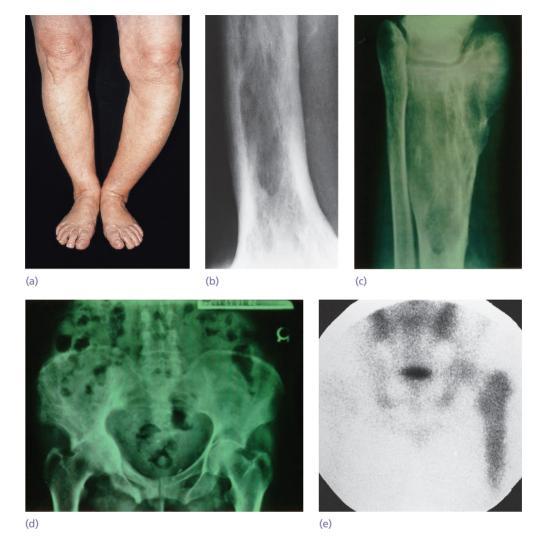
Paget's disease (a) Deformity of the tibia due to Paget's disease. (b) Flame-shaped area of osteopenia. (c,d) AP radiographs showing coarse trabecular patterning of the upper tibia and fibula (c), and right hemi-pelvis (d). (e) Radionucleotide scan showing increased activity in the left femur.
